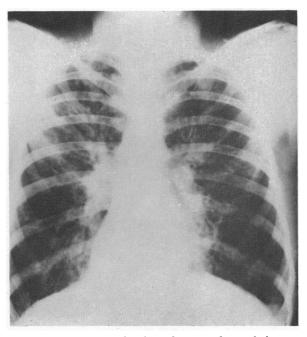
X-ray of the chest showing advanced changes consisting of air trapping and perihilar infiltrates extending particularly into the upper lobes.
